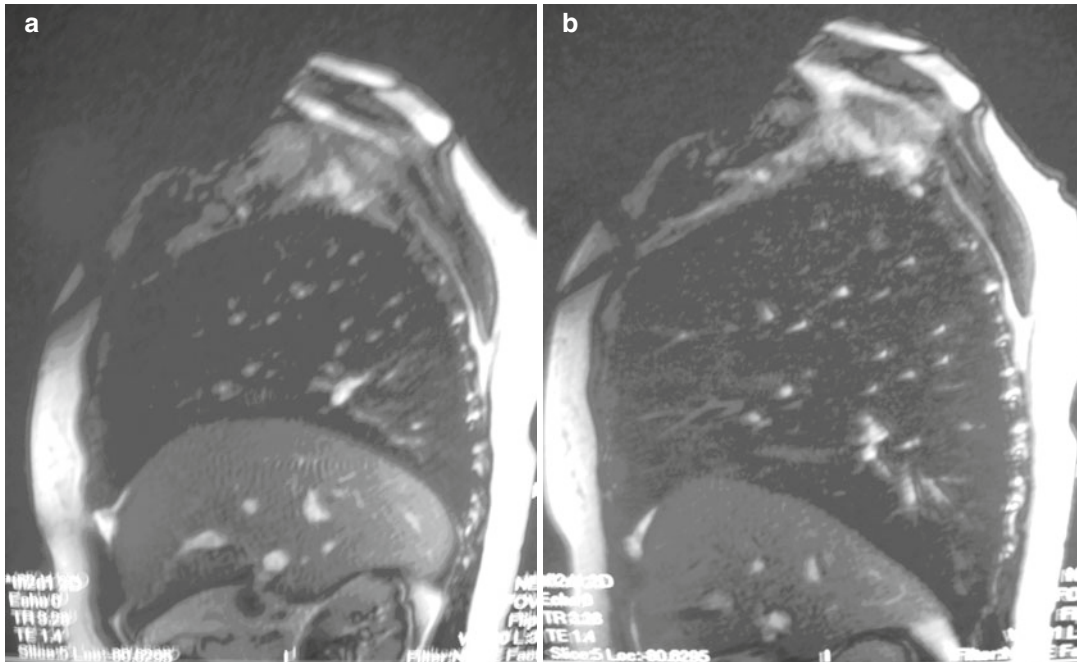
(a) Dynamic MRI imaging used to measure the movement of the diaphragm in maximum expiration. (b) Dynamic MRI showing diaphragm excursion in maximum inspiration
